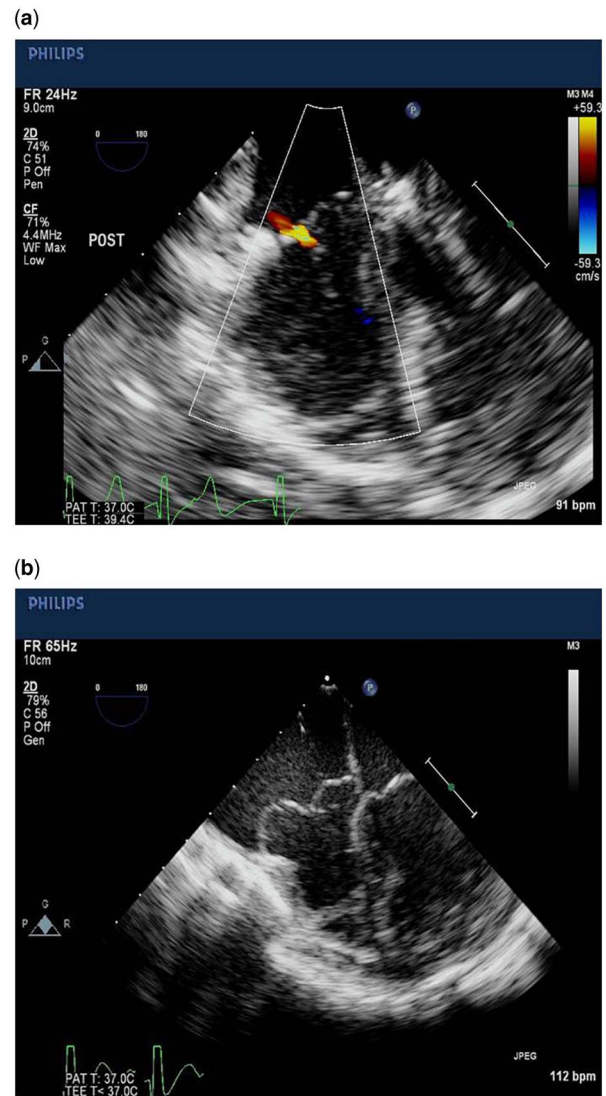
Echocardiogram shows an intact tricuspid prosthetic ring in a 21-month-old female with Marfan syndrome who presented with severe mitral and tricuspid regurgitation. The mitral and tricuspid annular dimensions allowed for adult-sized rings to be placed in both the tricuspid (28 mm) and mitral (30 mm) valves. (a) Upper segment colour flow Doppler echocardiogram shows the trivial amount of tricuspid regurgitation after ring annuloplasty. (b) The lower segment shows the anatomic configuration with excellent coaptation. The significant prolapse owing to elongated chordae remains, however.⁵
